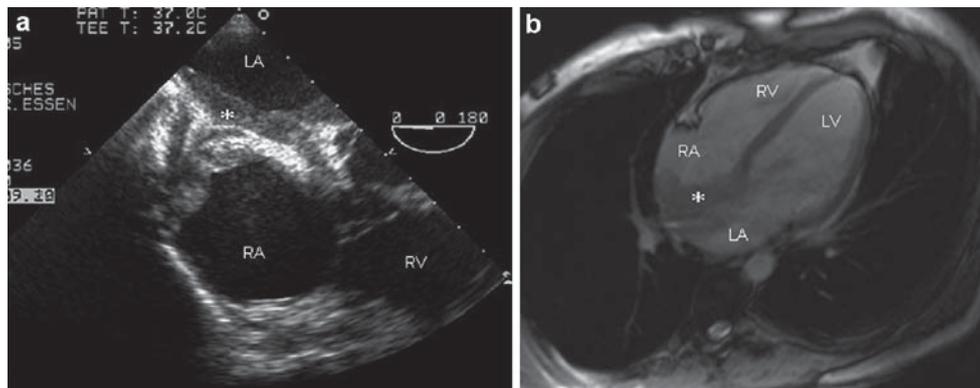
Primary cardiac lymphoma in a 25-year-old male patient with acute myeloid leukemia. Trans-oesophageal echocardiographic imaging (a) shows massive growth of a heterogeneous tumour mass (*asterisk*) within the inter-atrial septum with infiltration of the right atrial roof. Cardiac MR (b) reveals tumour manifestation beginning in the right atrial roof or superior vena cava entrance, which is walled in by the tumour, and tumour growth up
